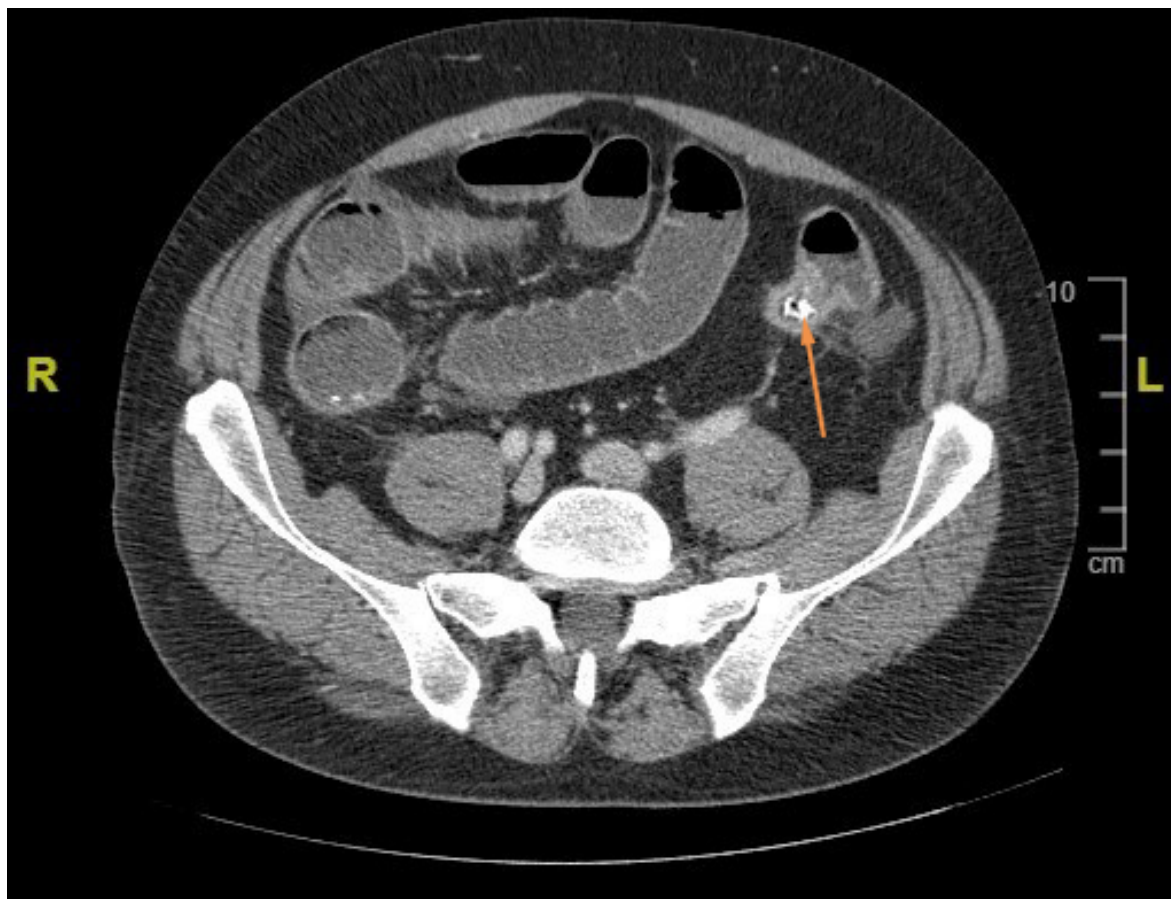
Computed tomography (CT) scan showing intestinal obstruction. The arrow indicates the malignant stenosis. R, right; L, left.
